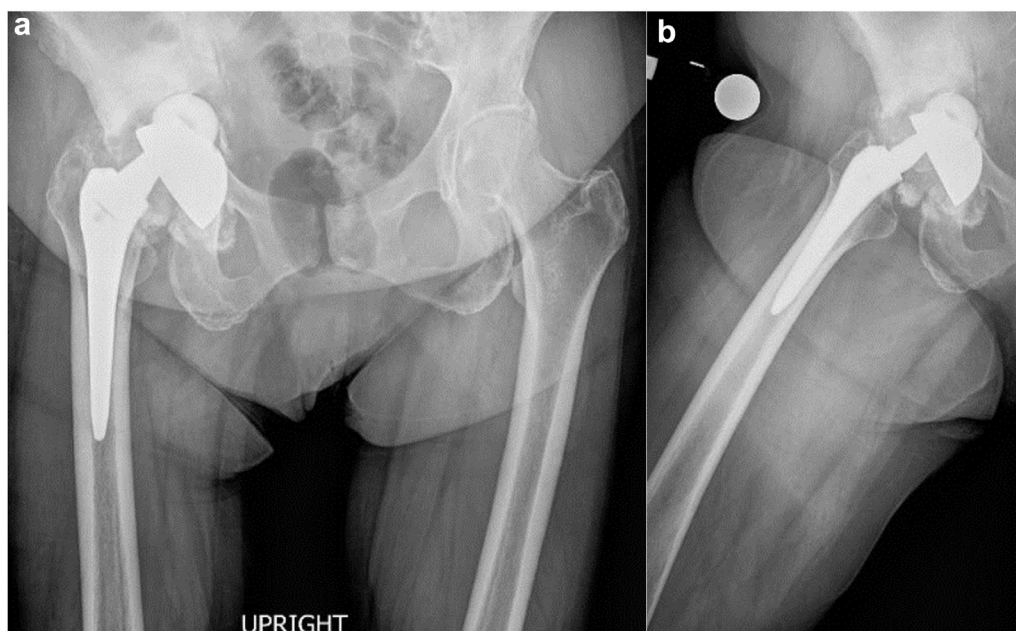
Anteroposterior (AP) pelvis (a) and (b) lateral radiographs at presentation.
